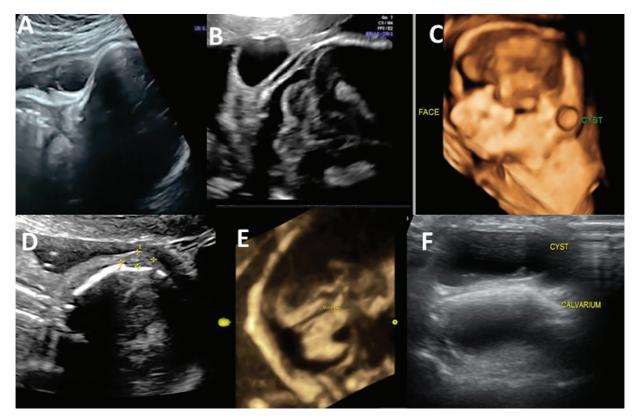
(A) Case 4: Transabdominal ultrasound image of the fetal head at 31 weeks showing 2.3×2.2 cm sized, thick walled cystic lesion in the left cervico-occipital region with normal intracranial anatomy and head circumference. (B, C) Case 5: (B) Transabdominal ultrasound image of fetal head at 22.2 weeks showing 1.7×1.6 cm sized cystic lesion is seen over the lower end of the occipital bone, toward the left side, behind the left ear with normal head circumference and intracranial anatomy. (C) Three dimensional (3D) surface rendering of the same cyst. (D, E) Case 6: (D) Transabdominal ultrasound image of fetal head at 23 weeks showing 0.6×1.2 cm sized cyst seen in the occipital region over the scalp with normal intracranial anatomy and head circumference. (E) 3D Omni view reconstruction of the posterior fossa of the brain shows Blake's pouch cyst. (F) Case 7: Postnatal ultrasound of skull showing epidermal cyst with intact calvarium.
